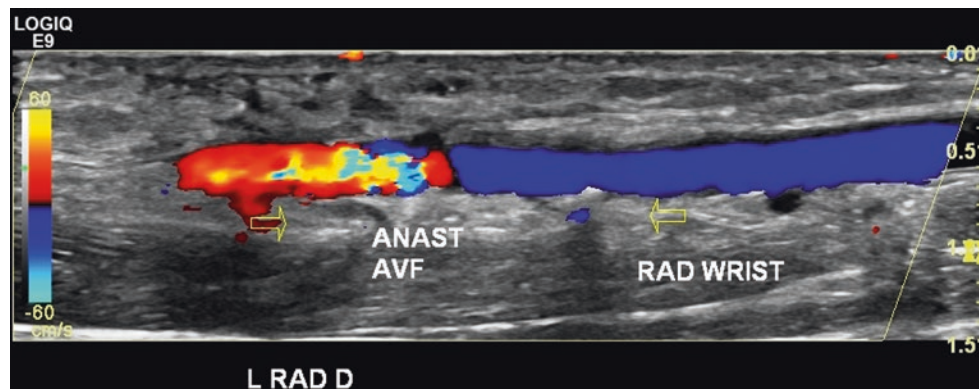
Color-flow Doppler image of a radial artery with a radial artery to cephalic vein anastomosis (ANAST AVF). The color-scale indicates antegrade flow up to the anastomotic site with retrograde flow
